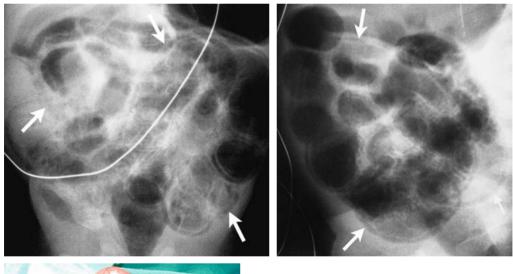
Pneumatosis intestinalis in a 1-week-old infant. Anteroposterior (a) and lateral (b) plain radiographs show small and large bowel loops sharply outlined by collections of gas in bowel wall. Most of these collections of gas are linear, indicating a submucosal location. c Surgical image of the same patient demonstrates diffuse bowel necrosis
